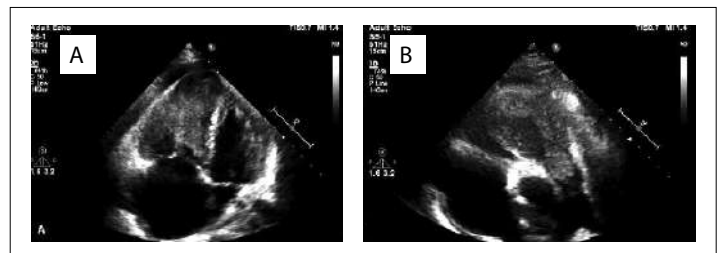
Echocardiogram showing the mass inside the right ventricle, which extended to the pulmonary artery and invaded the pulmonary valve, in apical four-chamber view (A) and parasternal short-axis view (B).
